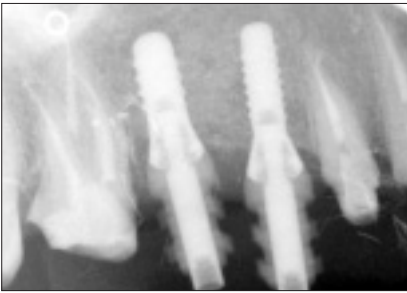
Radiograph showing proper adaptation of the impression copings to the fixtures.
